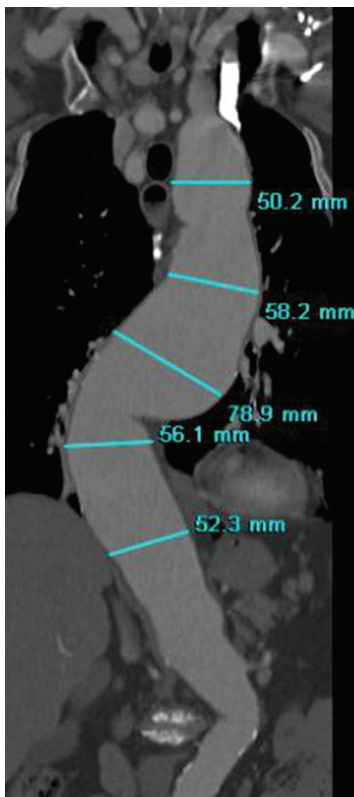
CT scan reconstruction of a thoracoabdominal aortic aneurysm, with measurements orthogonal to the long axis included.
